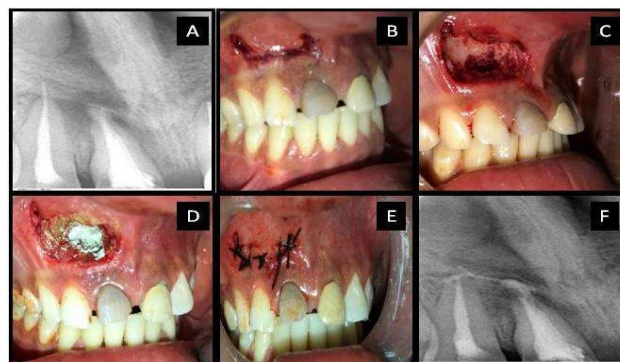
A- Radiographic view of obturated canals, B- Bleeding points marked, C- Flap raised, D- MTA placed, E- Suture placed, F- After surgery.
